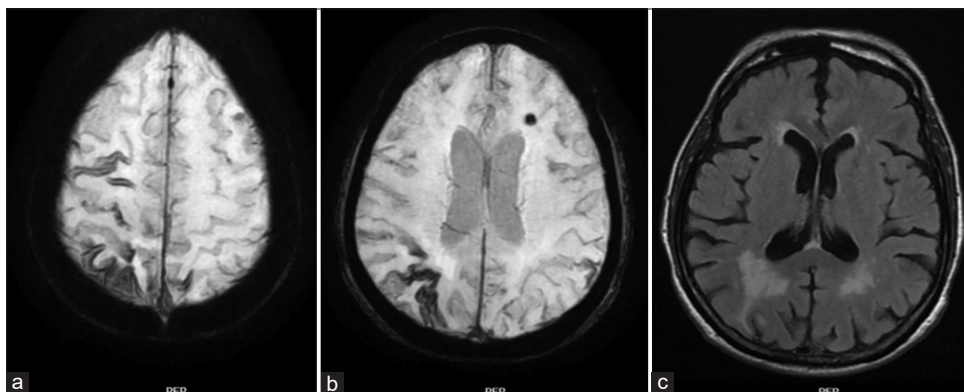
Minimum intensity projection images of the susceptibility-weighted imaging sequence shows (a) Sulcal subarachnoid hemorrhage in right superior frontal, pre-central and post-central sulci; (b) Sulcal subarachnoid hemorrhage in the right intraparietal sulcus and punctate microhemorrhage in the left frontal lobe. (c) T2 FLAIR images of the brain show multiple patchy and punctate foci of T2 hyperintensities involving bilateral periventricular white matter and subcortical white matter of bilateral frontoparietal lobes
